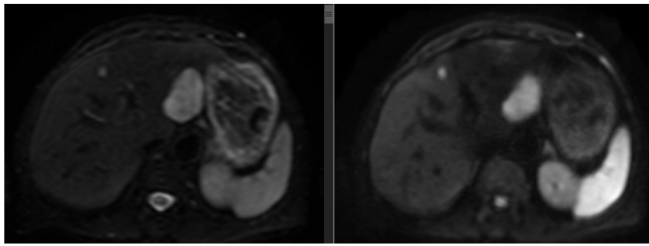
DWI sequences revealing restricted diffusion hyperintense lesions on left and right liver lobes.
